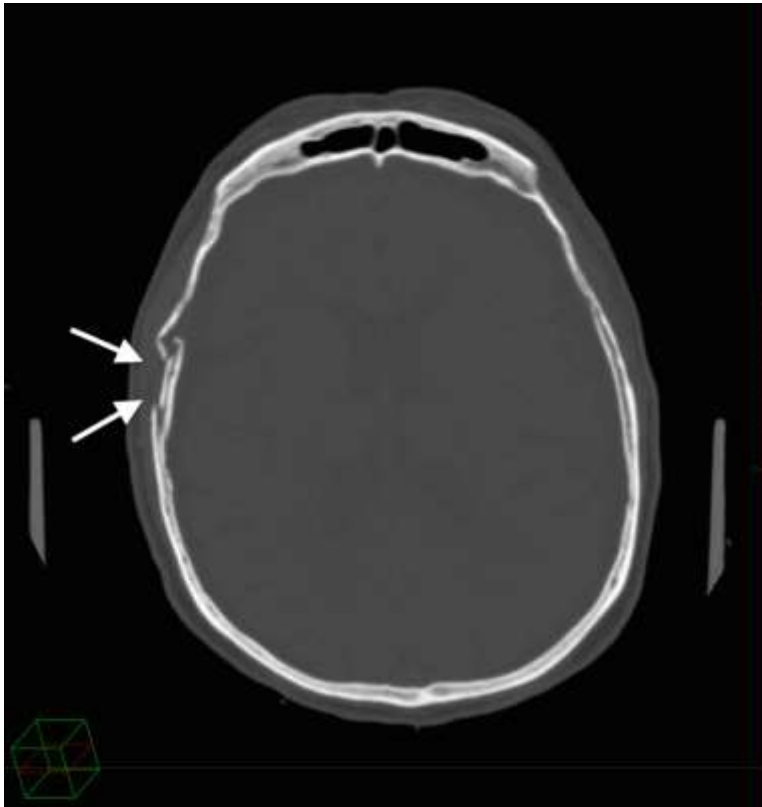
CT scan showing a right temporal bone fracture.
